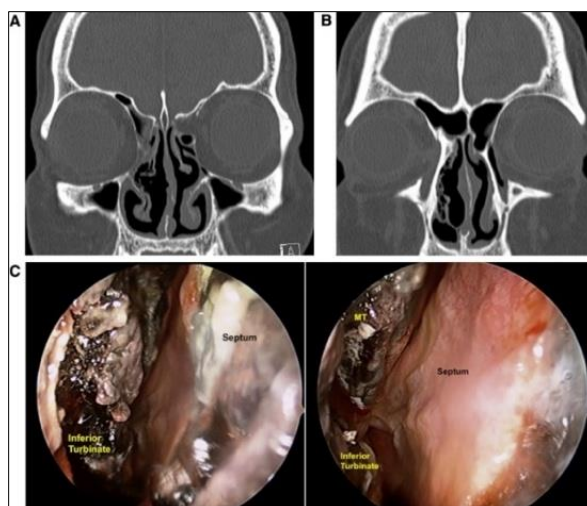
CT images of acute invasive fungal rhinosinusitis. (A, B) A non-contrast CT scan shows submucous emphysema in (A) the right middle and inferior conchae and (B) the lateral nasal wall. (C) Endoscopic examination of the right nasal cavity, showing necrotic tissue in the right inferior conchae and the anterior part of the nasal septum. Endoscopic image of the right nasal cavity also shows necrotic tissue extending to the middle and inferior conchae⁵
